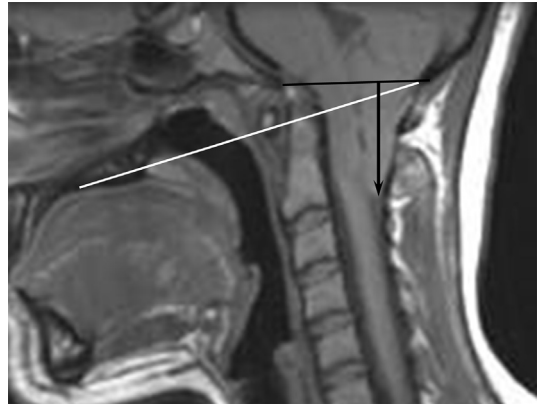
Chiari I malformation. Sagittal T1-weighted image shows a black line along the foramen magnum and a black arrow depicting the severe herniation of cerebellar tonsils below the foramen magnum. Because the arrow is longer than 5 mm, and there is no posterior fossa mass or mass effect, this patient has a Chiari malformation. Note the associated basilar invagination, with the anterior arch of C1 and dens extending superior to Chamberlain line (*white line*).
